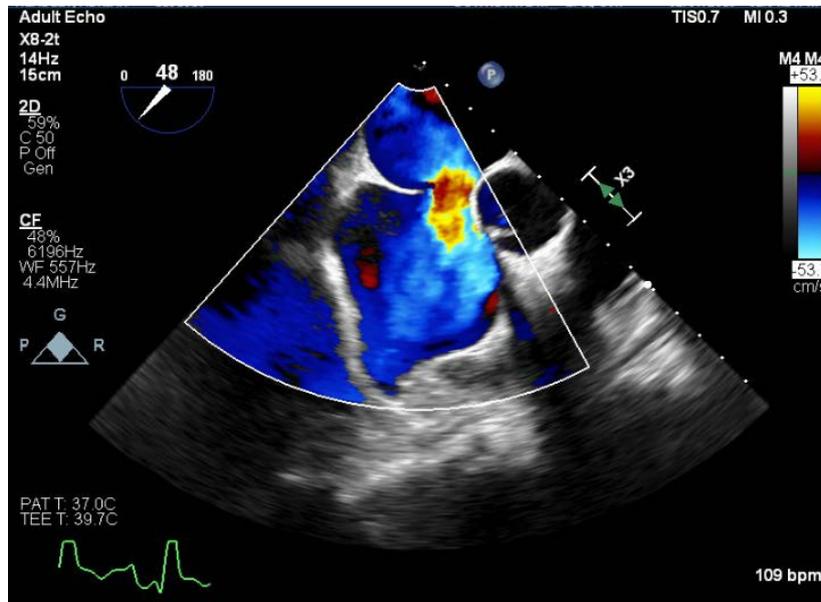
Transesophageal echocardiography which revealed large secundum septal defect measuring 20 mm with left to right flow
